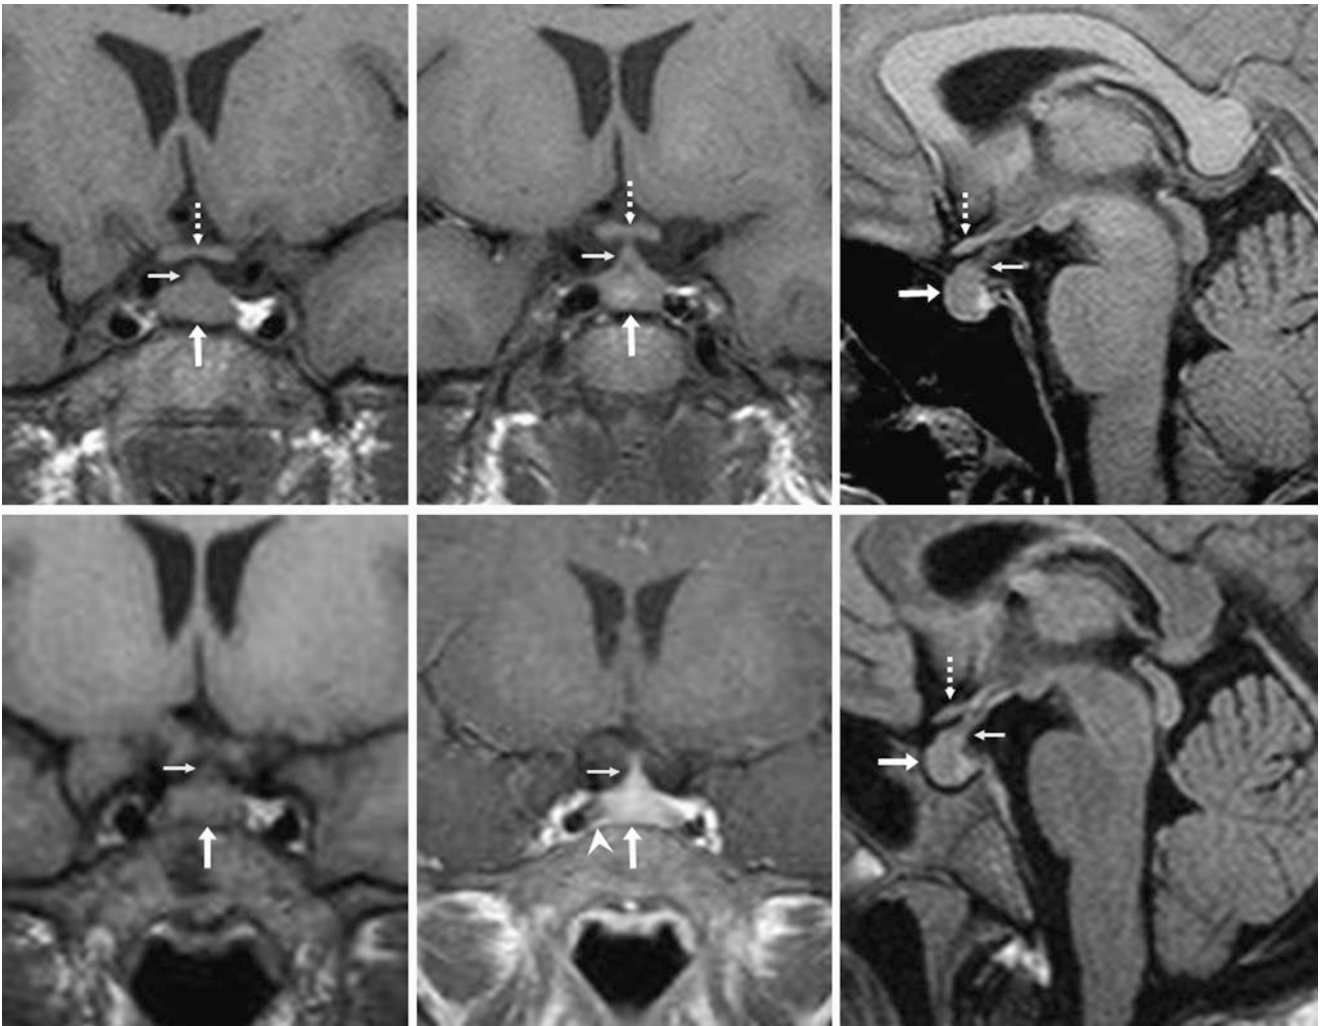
A 21-year-old female with visual symptoms and pituitary hypertrophy (*arrows*) on 1.5 T MRI noncontrast coronal (*top left and middle*) and sagittal (*top right*) T1WIs. The ophthalmologist considered the symptoms to be unrelated. Seven years later, pre- (*bottom left*) and postcontrast (*bottom middle*) coronal T1WI and noncontrast sagittal
